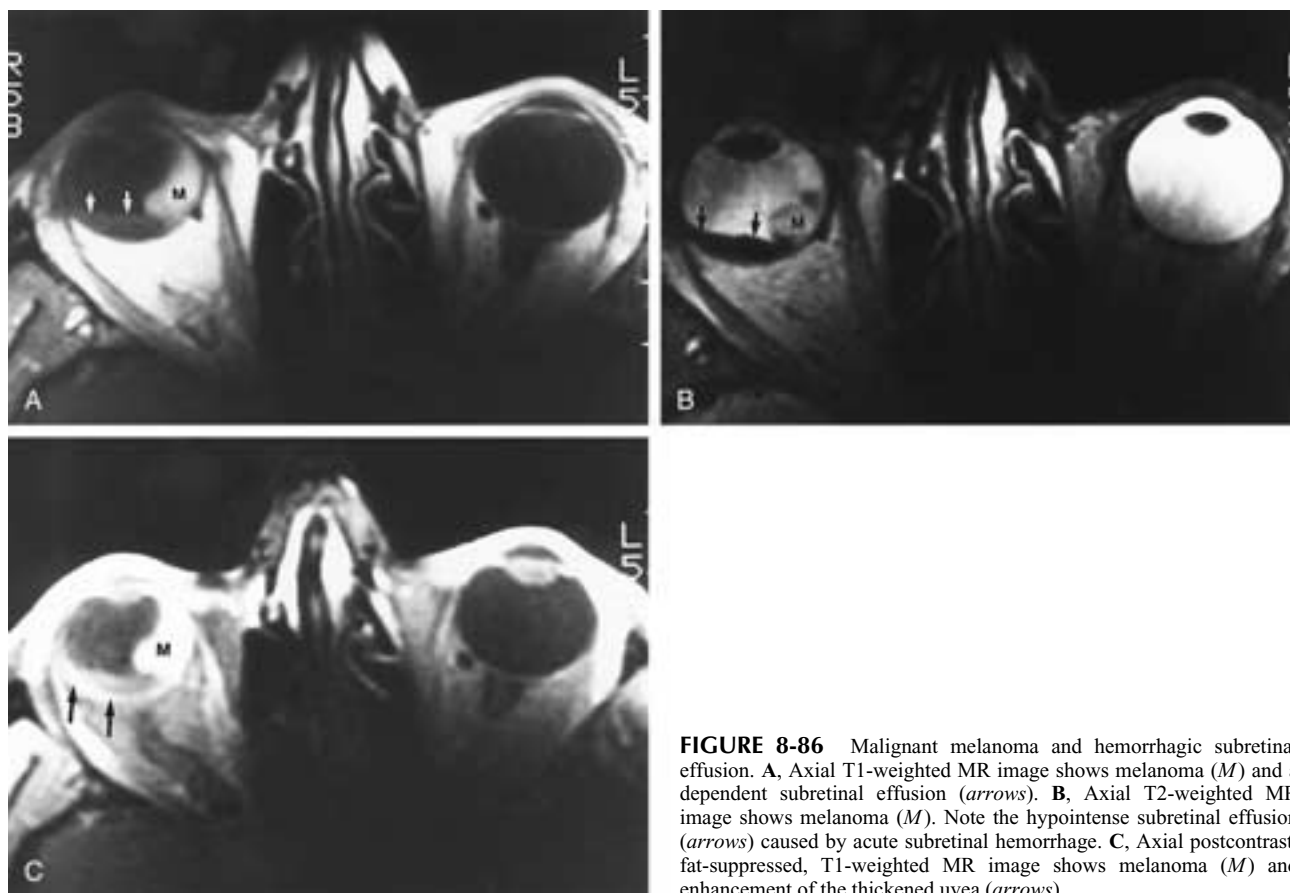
Malignant melanoma and hemorrhagic subretinal effusion. A, Axial T1-weighted MR image shows melanoma (*M*) and a dependent subretinal effusion (*arrows*). B, Axial T2-weighted MR image shows melanoma (*M*). Note the hypointense subretinal effusion (*arrows*) caused by acute subretinal hemorrhage. C, Axial postcontrast, fat-suppressed, T1-weighted MR image shows melanoma (*M*) and enhancement of the thickened uvea (*arrows*).
